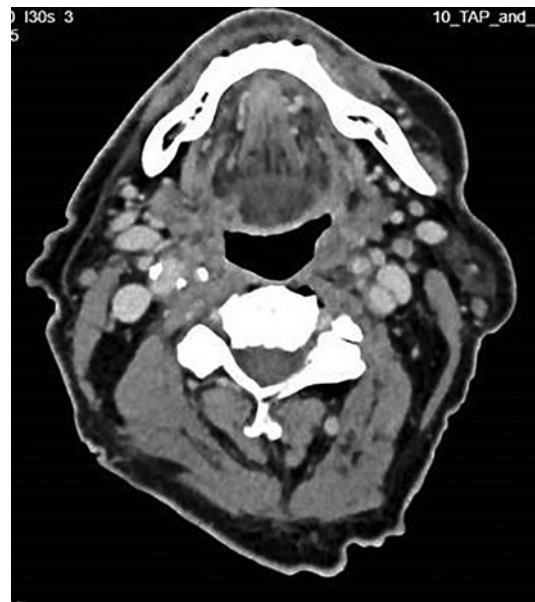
Axial slice of contrast-enhanced CT neck post-cycle 6 nivolumab showing interval reduction in neck mass.
